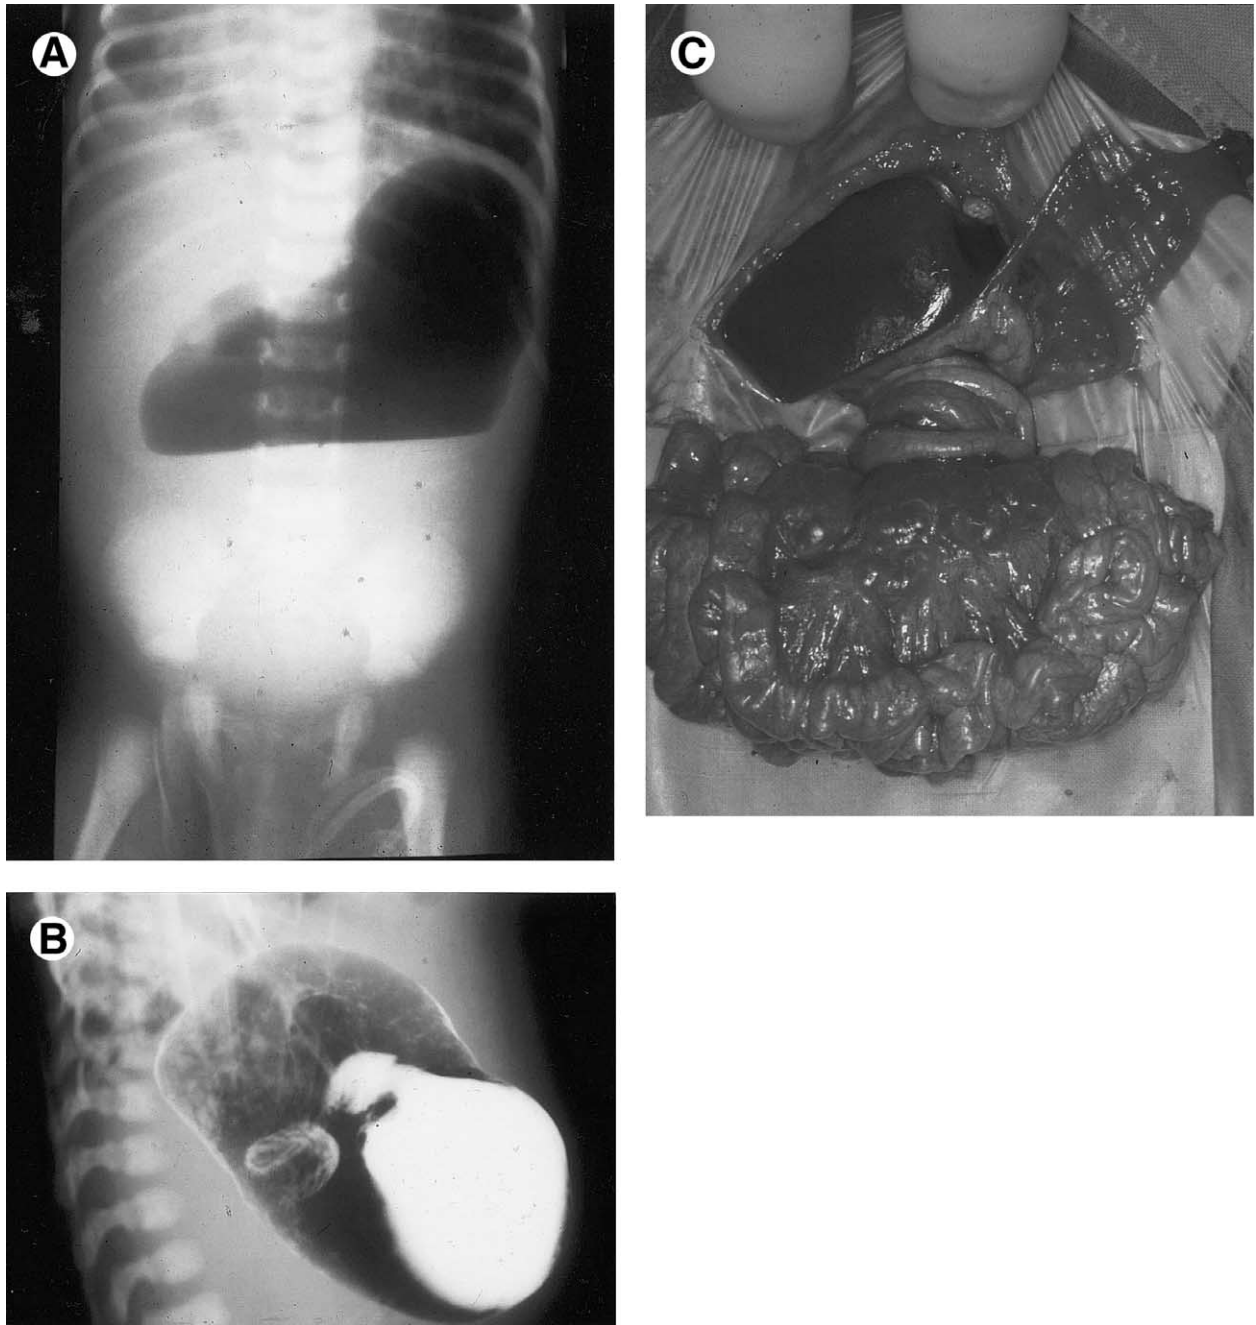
(A) Erect abdominal radiograph of a 1-month-old infant presenting with 36 hours of bilious vomiting. A previous episode the week before had settled with conservative management. (B) Note the near-complete duodenal obstruction with the typical corkscrew appearance of the duodenum on contrast meal (oblique view). (C) Laparotomy revealed 720° clockwise midgut volvulus with lymph node enlargement but otherwise healthy bowel.
